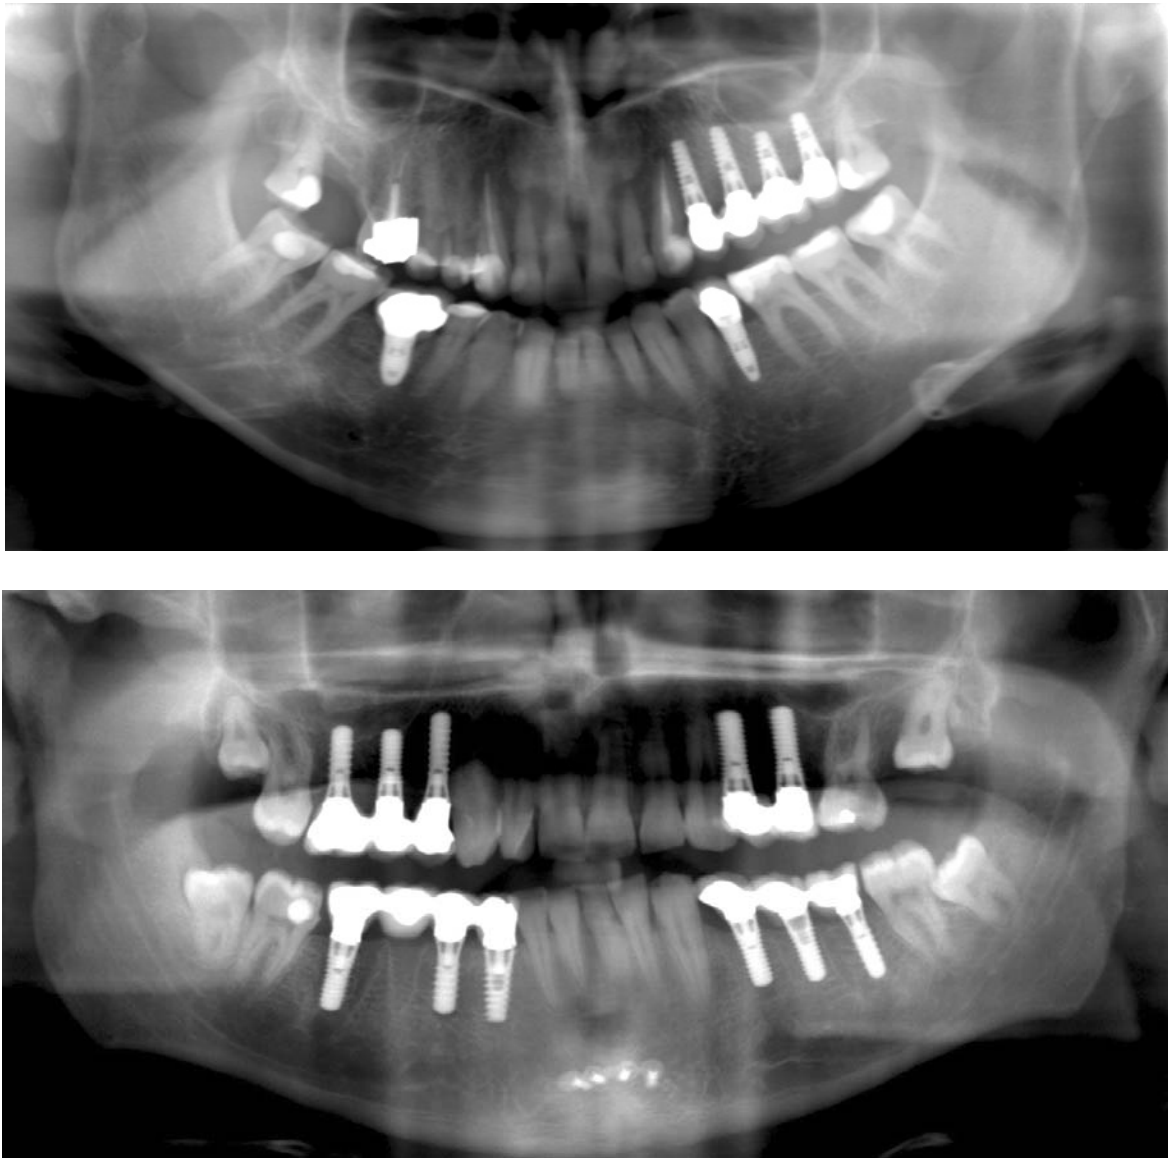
Postoperative radiographs of patients
